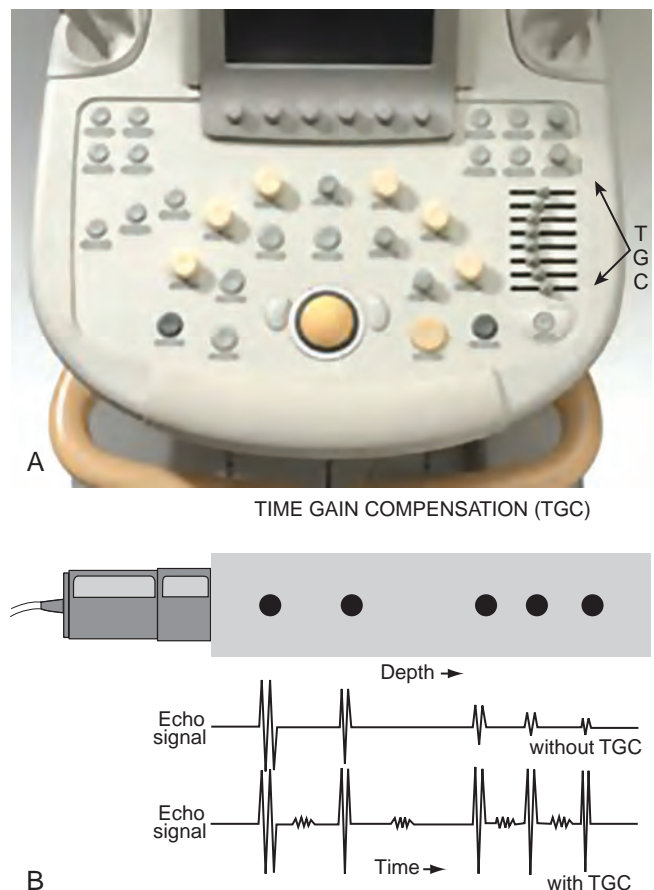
(A) Ultrasound control panel that shows the time gain compensation (TGC) controls along the right side of the panel. (B) The TGC allows the sonographer to amplify the receiver gain gradually at specific depths to adjust for attenuation.
